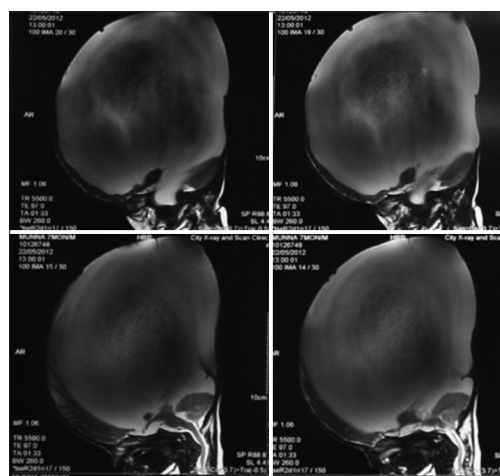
Sagittal section MRI showing enlarged ventricles with a normal-sized fourth ventricle
